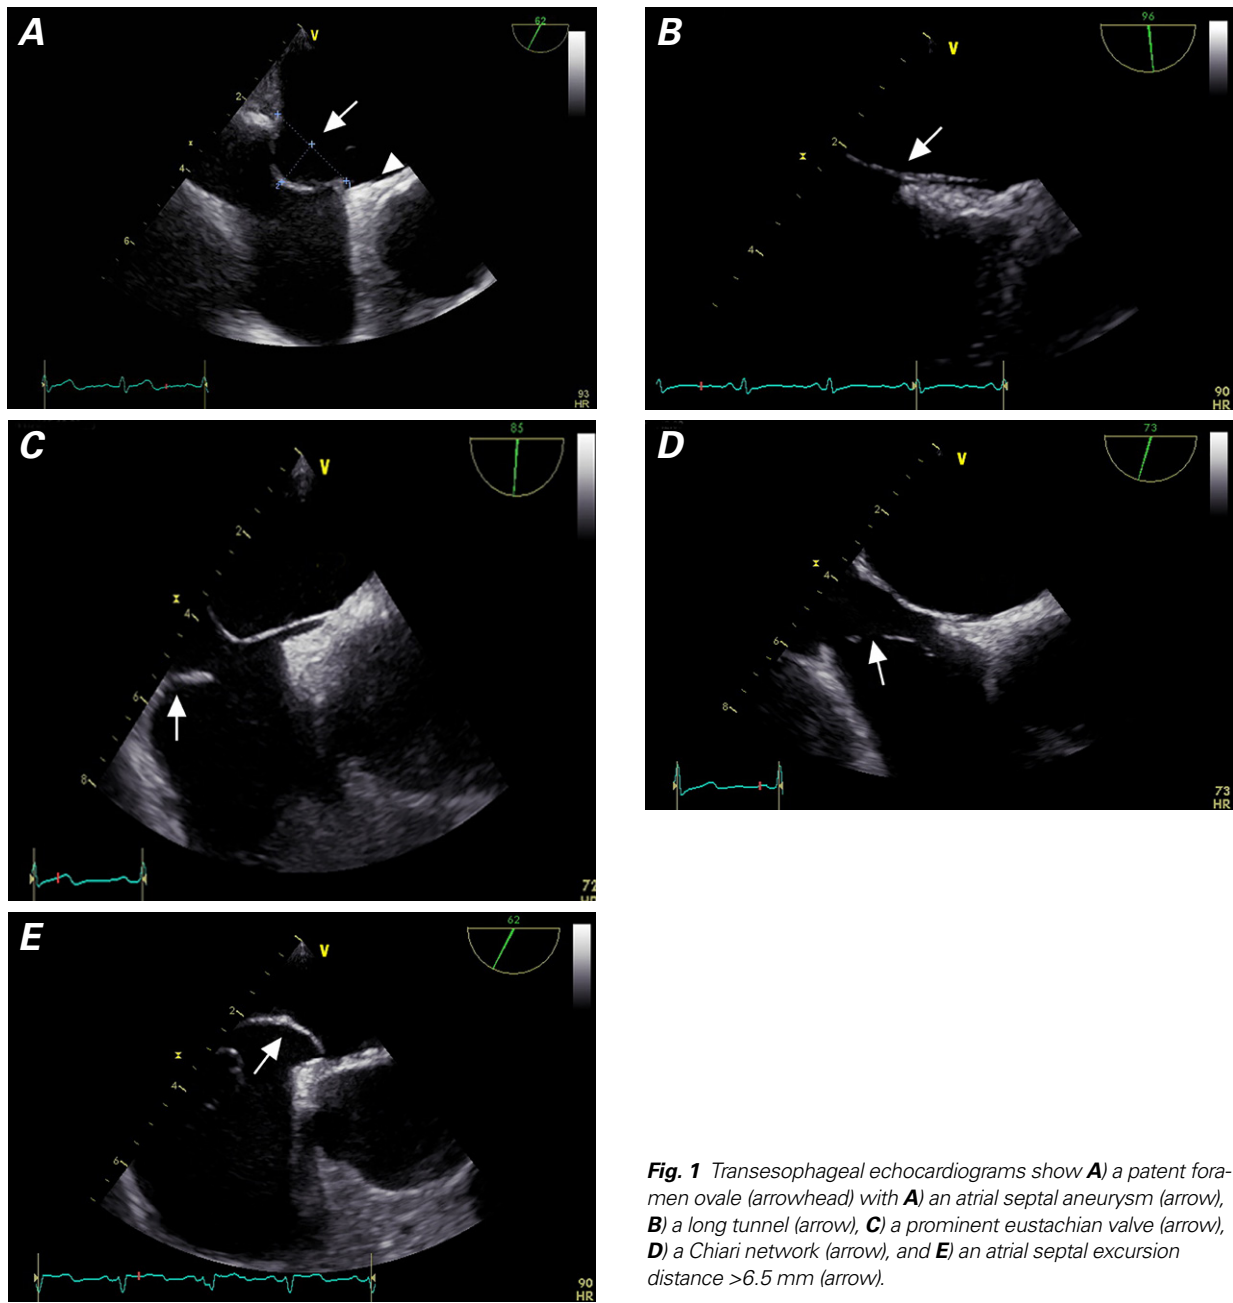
Transesophageal echocardiograms show A) a patent foramen ovale (arrowhead) with A) an atrial septal aneurysm (arrow), B) a long tunnel (arrow), C) a prominent eustachian valve (arrow), D) a Chiari network (arrow), and E) an atrial septal excursion distance >6.5 mm (arrow).
